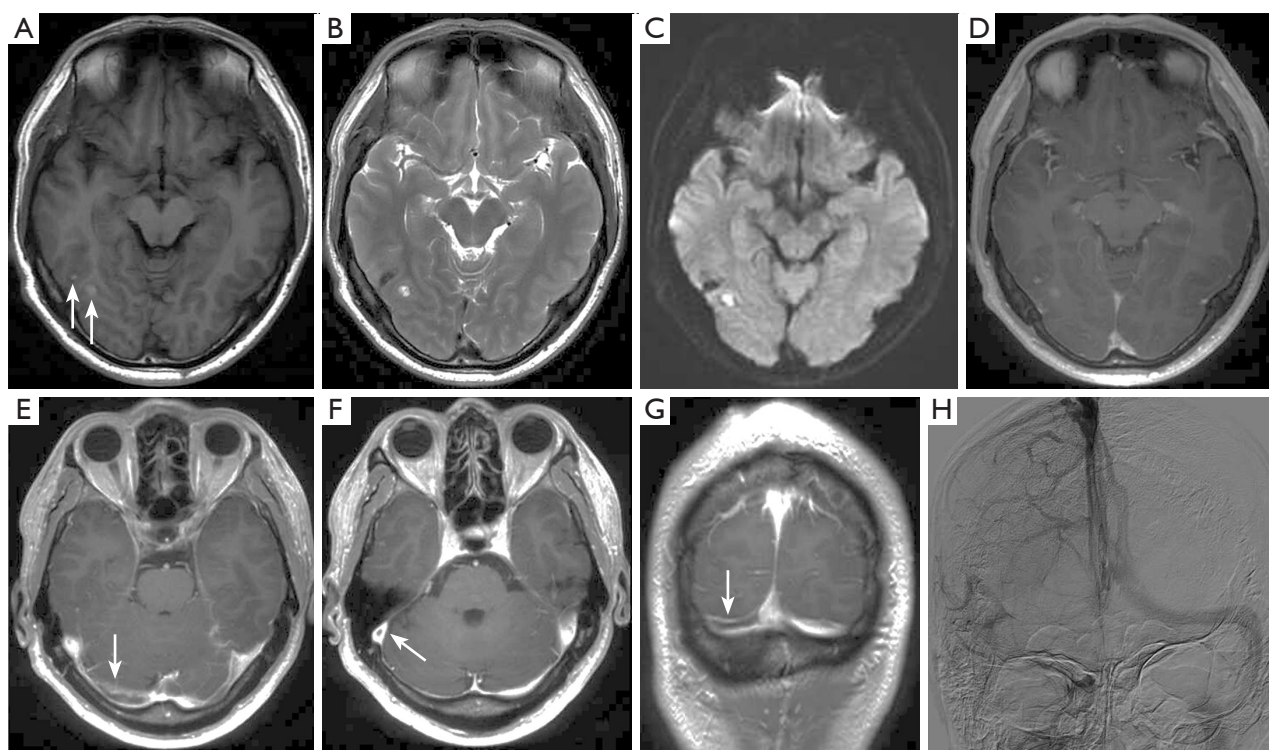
Blind spot in brain imaging: dural sinuses. Scans of a 42-year-old male with a 2-week headache and dizziness. (A-D) MRI showed two nodular abnormal signals in the right temporo-occipital lobe (arrows). Given the signal characteristics, radiologists diagnosed them as hemorrhagic foci. (E-G) MRI T₂WI/FLAIR showed hypointense lesions within the right transverse sinus and straight sinus (arrows). (H) DSA confirmed the presence of a venous sinus thrombosis. The final diagnosis was secondary intracranial hemorrhage following CVST. MRI, magnetic resonance imaging; T₂WI/FLAIR, T2-weighted image/fluid-attenuated inversion recovery; DSA, digital subtraction angiography; CVST, cerebral venous sinus thrombosis.
